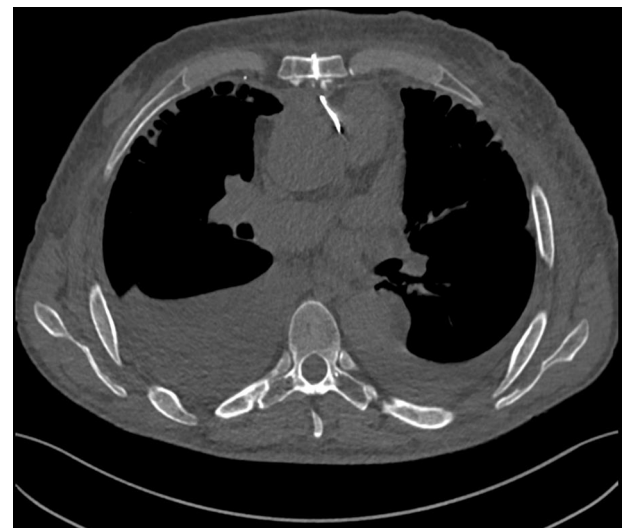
Axial CT scan of the thoracic aorta showing the suture thread directed towards the ascending aorta.
